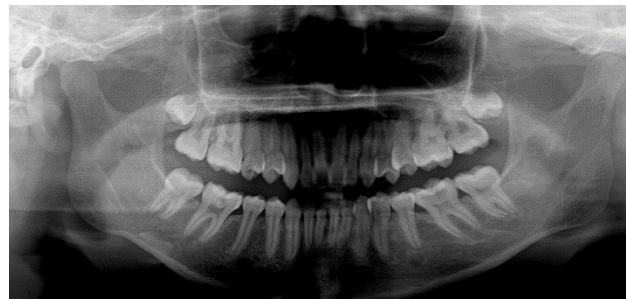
Digital panoramic radiograph samples of respondents
